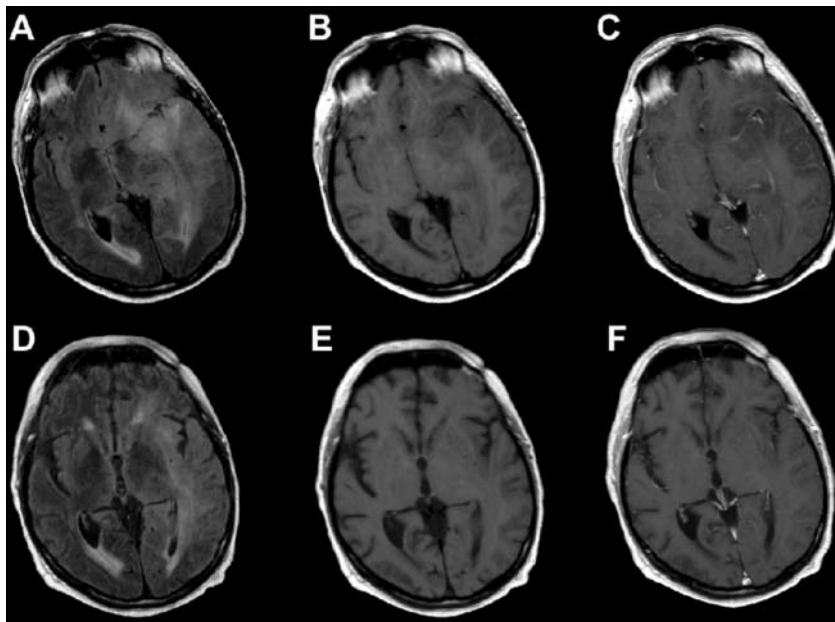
Time course of gliomatosis-associated cerebral lesions in T2-weighted imaging of patient 1. Gliomatosis cerebri-induced space-occupying effects such as compression of the left lateral ventricle and midline shift are clearly regressive between June 2006 (A-C) and February 2007 (D-F). All images acquired on a 1.5 Tesla MRI-unit: A, D: FLAIR sequence; B, E: non-enhanced T1-weighted imaging; C, F: contrast-enhanced T1-weighted imaging.
